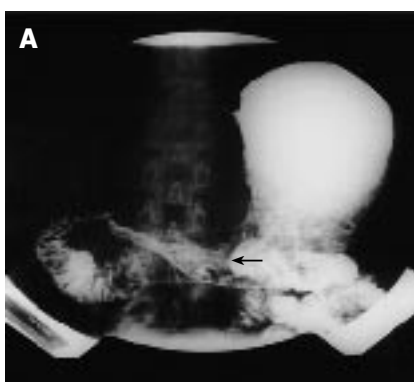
Double-contrast upper GI examination demonstrating irregular narrowing of the gastric antrum (arrow) (A), CT demonstrating gastric mural thickening, perigastric stranding, (arrow) and lymphadenopathy (B).
